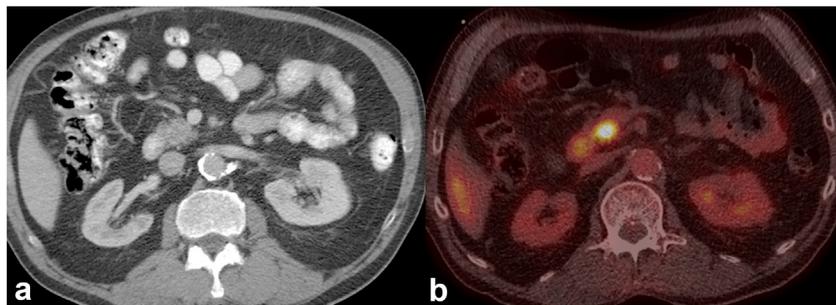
A 77-year-old male with a small (25 mm) poorly differentiated T2N2 PDAC of the pancreatic head who underwent pancreatoduodenectomy with an overall survival of 6 months. The tumor was isoattenuating on CECT (a) and showed homogeneous high [^{18}F]FDG-uptake on PETCT (b)
